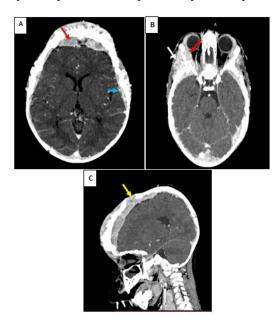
Cerebral CT scan with injection (Parenchymal window): (A) Axial section: frontal epidural tissue deposits (red arrow) with leptomeningeal enhancement (blue arrow). (B) Axial section: Infiltration of the jugal soft tissues (white arrow) and lateral rectus muscles (red arrow). (C) Sagittal section: Epidural deposits reaching the vertex and insinuating between the margins of the coronal suture (yellow arrow).
